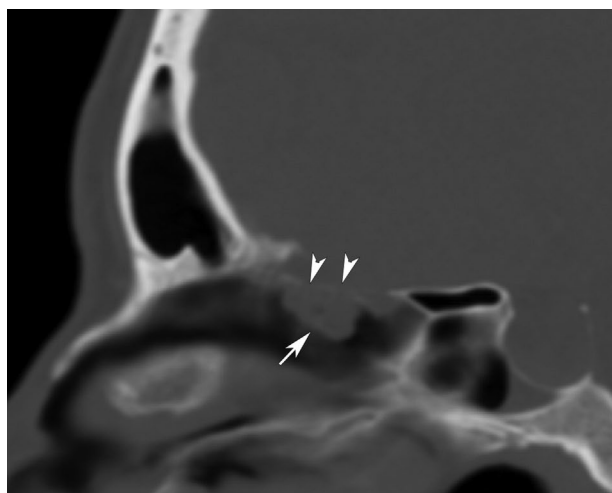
Sagittal multiplanar reconstruction CT in a patient with posttraumatic rhinorrhea shows presence of a defect involving the cribriform plate (arrowheads) along with lobulated, herniating soft tissue (arrow), consistent with a meningocele.
